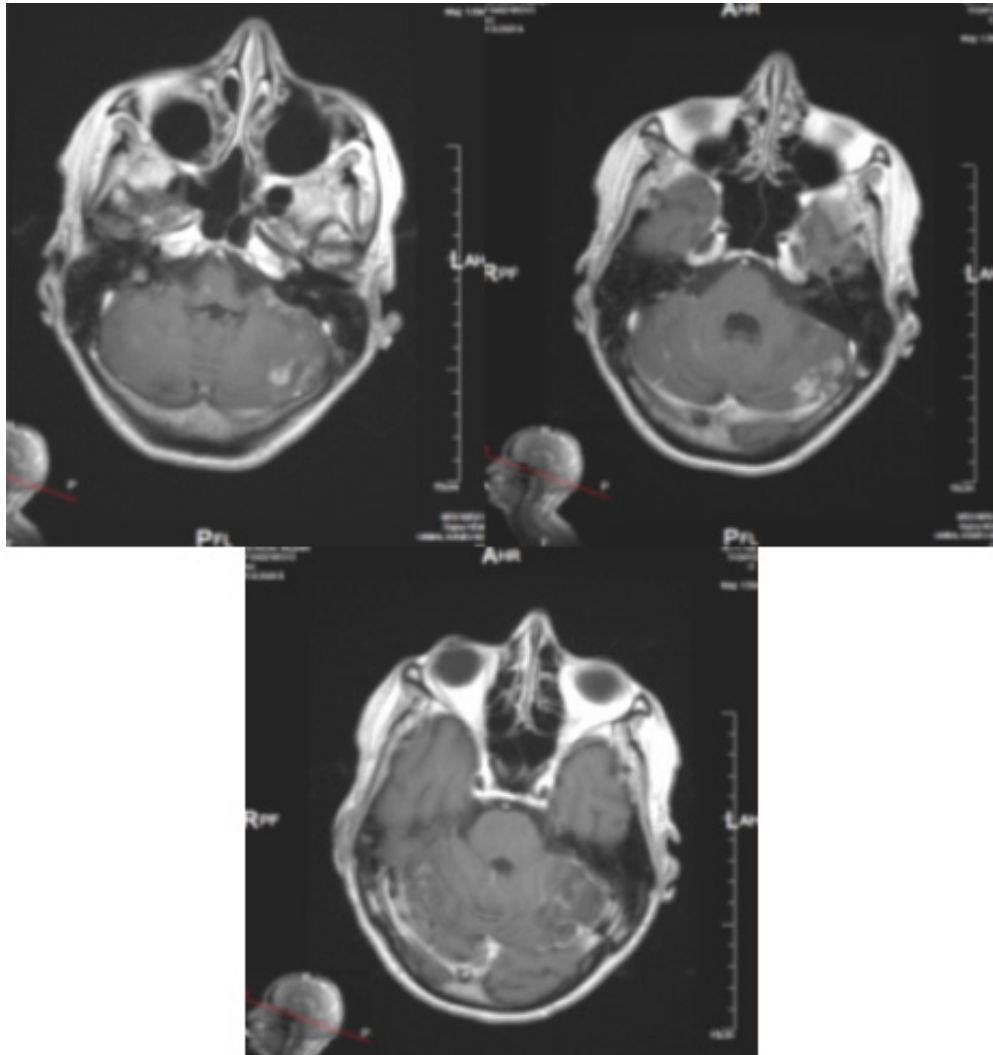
AX T1 FLAIR MRI after 4 months of RT and 3 months of targeted therapy alone.
